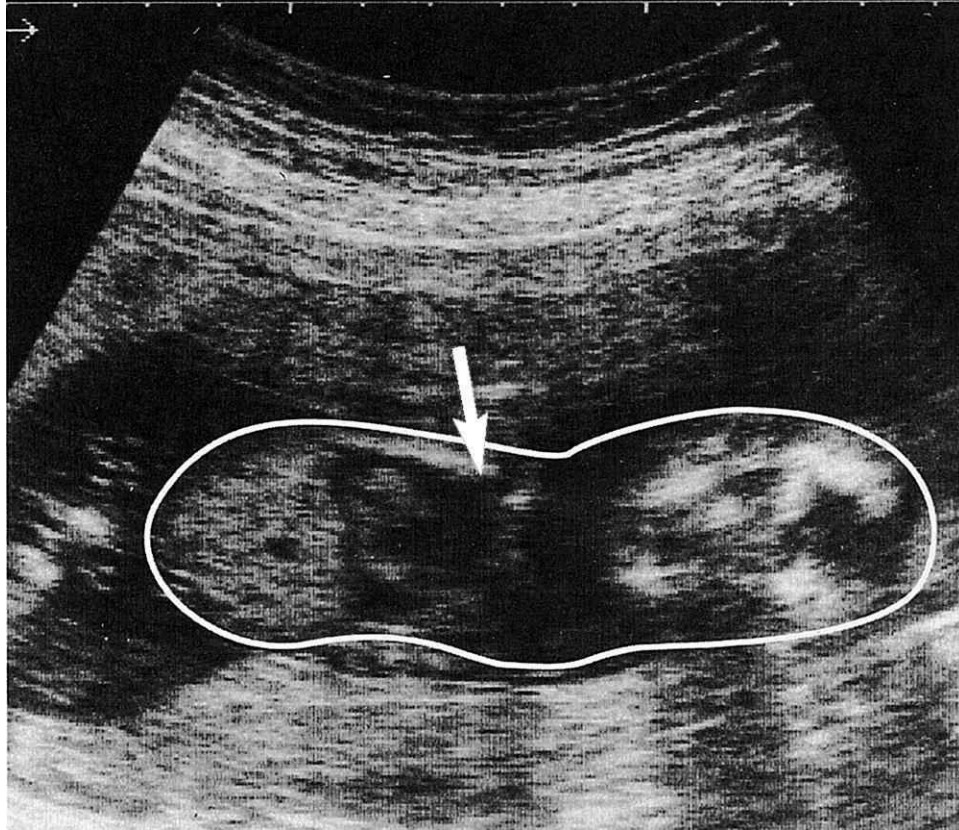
Longitudinal ultrasonographic scan of a coronal section of the head (to the right) and thorax of a fetus with hydrops fetalis from the severe form of α -thalassemia, Hb Barts, showing a large pleural effusion (arrow). Courtesy Mr J. Campbell, St. James's Hospital, Leeds, UK.
